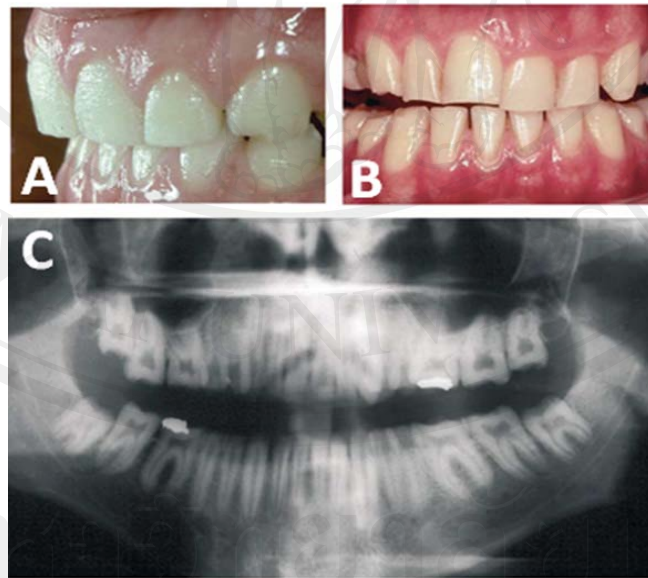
(A and B) Both affected individuals showed generalized hypoplastic enamel. (A) The dentition of the proband showed shallow horizontal pits on enamel while (B) the dentition of the relative showed smooth, worn enamel. (C) The radiographic examination of the relative showed very thin to absent enamel (Hart et al., 2003a).
